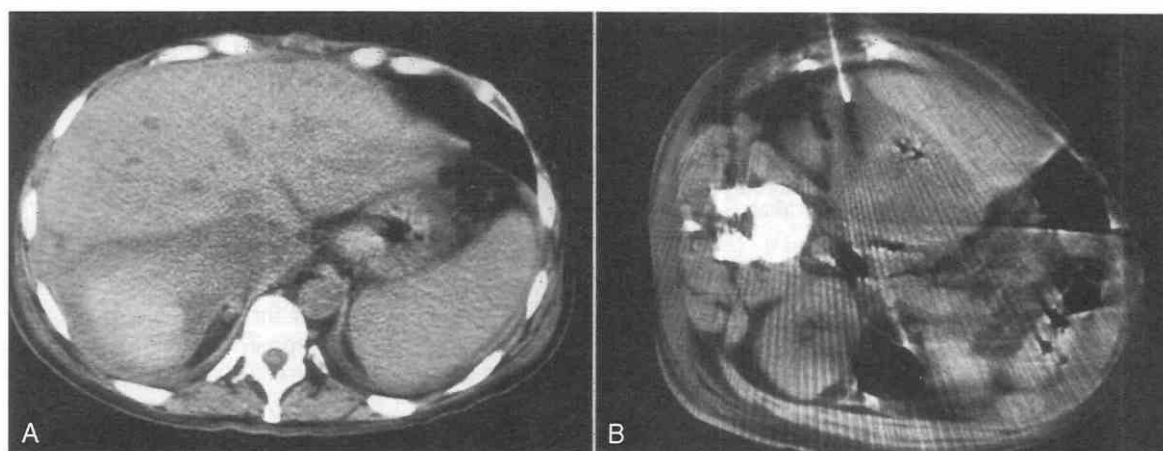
A, CT scan of a patient in the supine position shows a high-density fluid collection in the right subhepatic space. B, When the patient is positioned on the left side, the fluid remains in the same location and does not shift. Note the drainage needle in the right flank.
